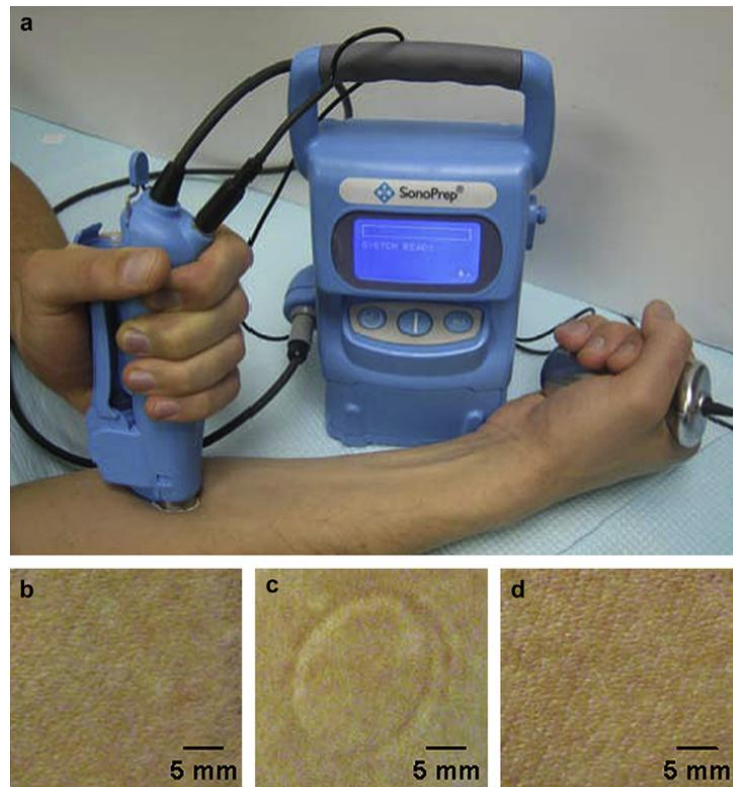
Sonication of the skin. (a) Sonication was carried out by applying a hand piece containing ultrasound coupling medium to the subject's volar forearm skin. A reference sensor clasped in the subject's hand helped determine the duration of sonication by interacting with the main control console. Photographs of a representative sonicated skin site are shown (b) immediately before sonication, (c) immediately after sonication and (d) 24 h after sonication. No erythema, edema or adverse events were associated with sonication at any time. Only a transient skin indentation caused by application of the hand piece was observed immediately after sonication (c).
